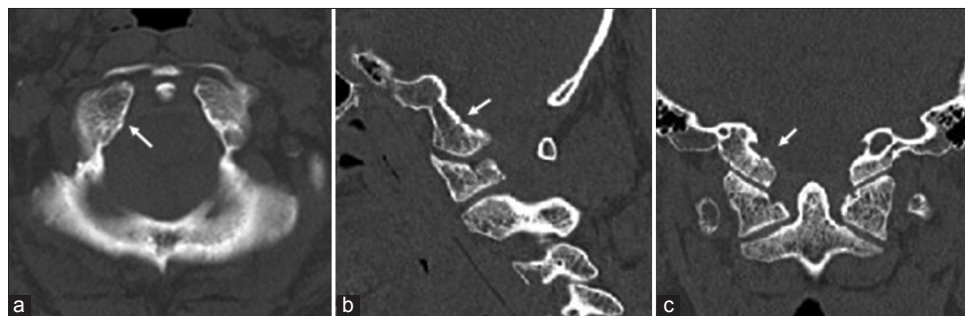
Computed tomography images 6 weeks after presentation. Axial image revealed that healing process had occurred at the fracture site (arrow) (a). Similar findings were confirmed in 1 reconstructed sagittal image (arrow) (b) and reconstructed coronal image (arrow) (c).
